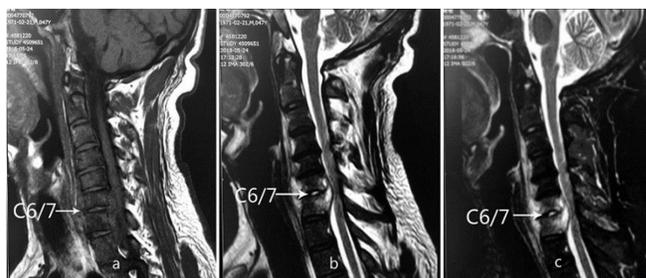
MRI of the cervical spine. T1-weighted images, a: reveals decreased signal intensity of C6 and C7 vertebrae and the intervening disk, as well as end-plate erosions and narrowing disc space. T2-weighted images, b: shows increased signal intensity of the C6+C7 disk and the adjacent vertebrae. Fat-saturated sagittal image, c: shows signal increase at the same level.
